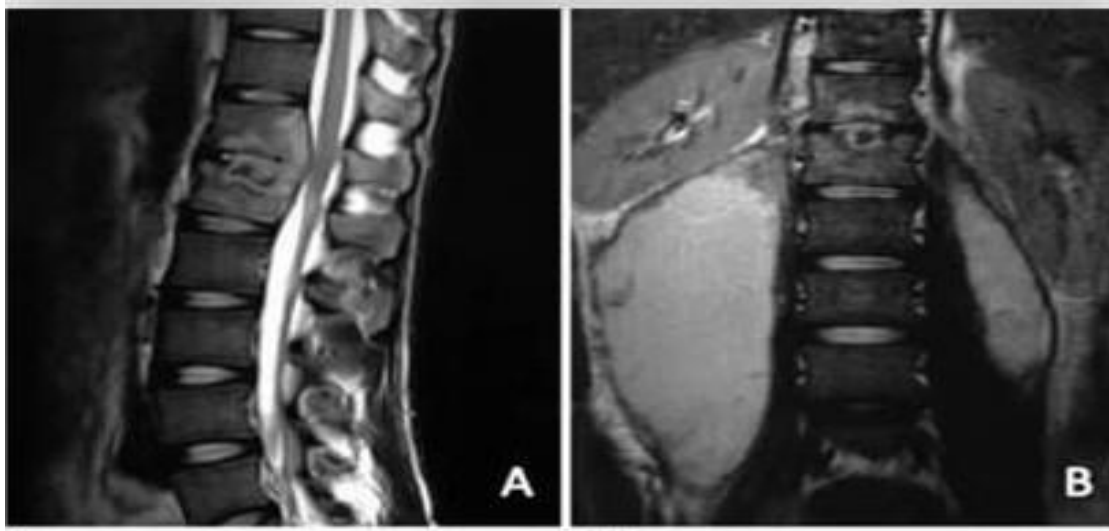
MRI showed bilateral psoas abscess in a male patient. A-Sagittal T2-weighted MRI demonstrated it. B-Coronal T2-weighted MRI demonstrated upward displacement of the right kidney because of the right huge psoas abscess.
